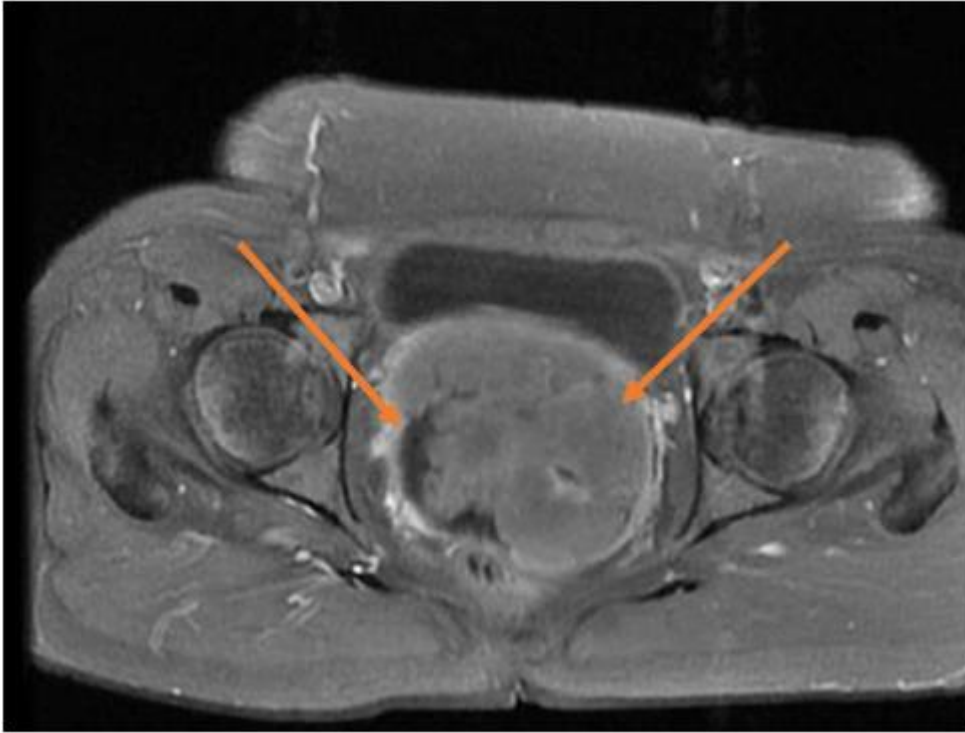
Cervical carcinoma with parametrial invasion. Axial T1 C+ fat sat MRI
